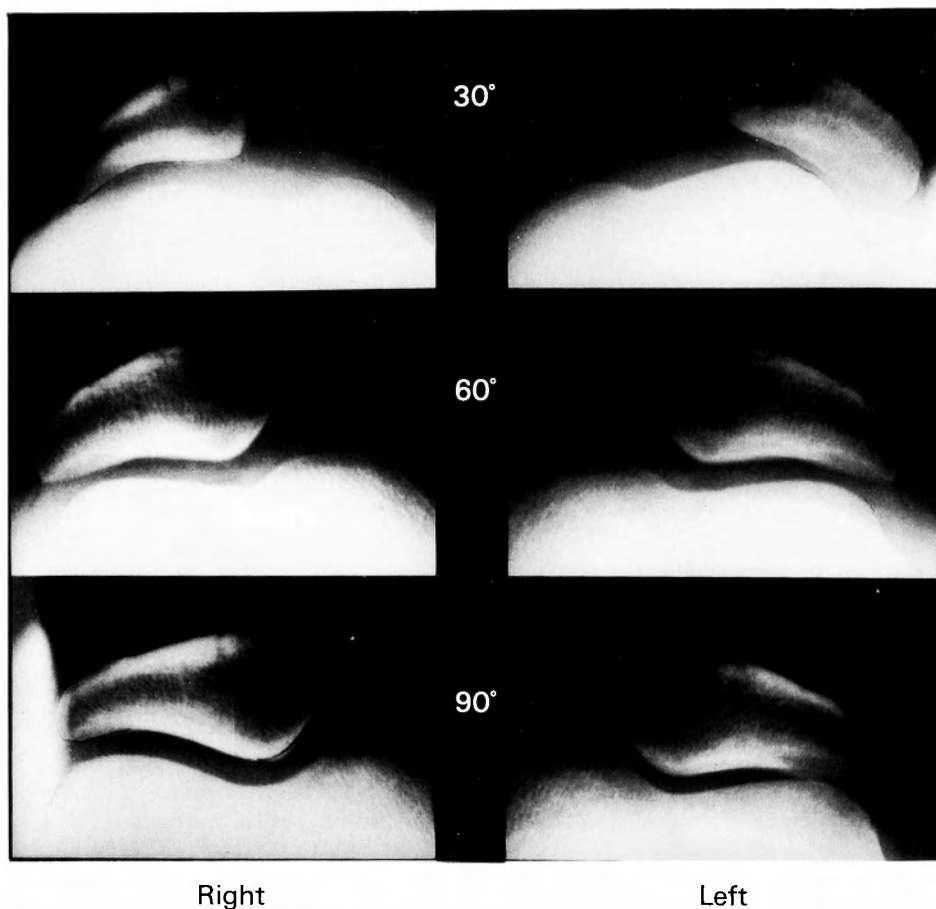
Roentgenogram in axial projection after three years of orthotic treatment. The right patella held in almost position. The left patella remains slightly subluxated, but the position of the patellae are much improved.
